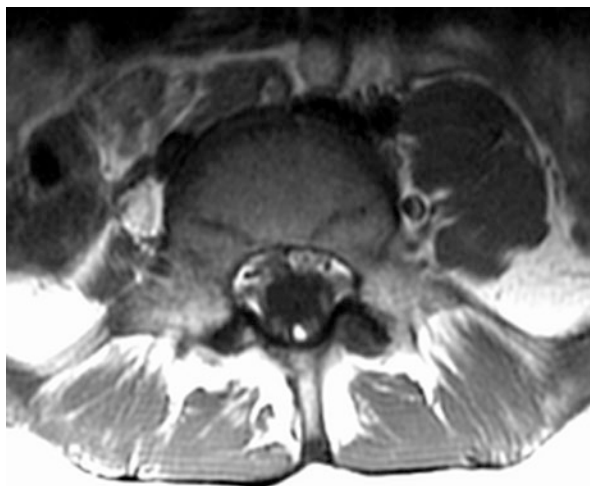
An 11-year-old female who remained unable to walk until 4 years of age. She presented with chronic progressive back pain, progressive lower extremity weakness, and progressive bladder incontinence. The figure shows a T1-weighted axial image of the mid-lumbar spine depicting a thick and fatty filum terminale. The conus medullaris is low lying, terminating at the mid-L3 vertebral level. This case represents a typical symptomatic TCS patient
